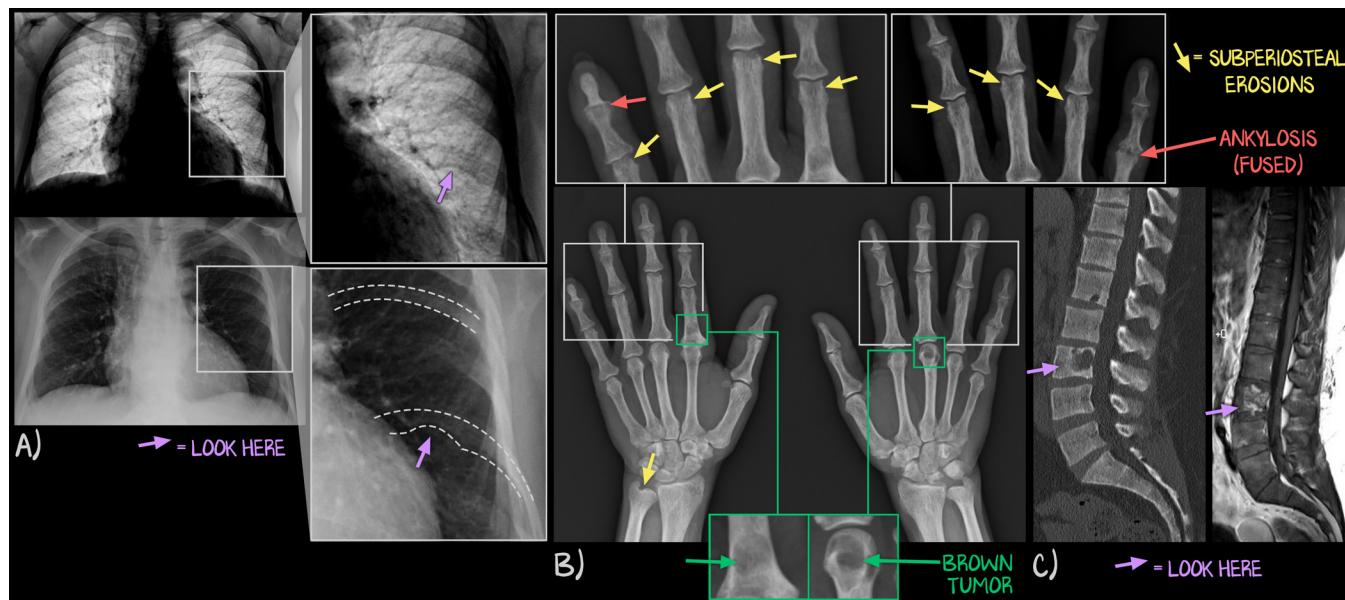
Radiographic Osteitis Fibrosa Cystica
